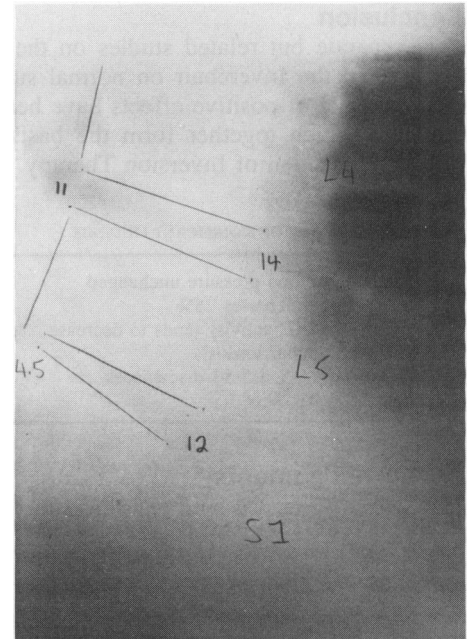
Patient #2. Pre-Inversion radiograph.
